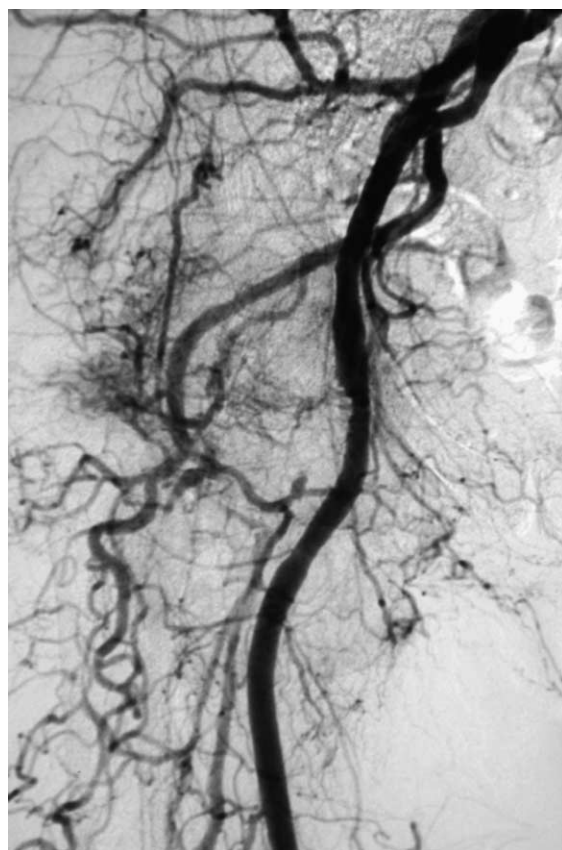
Vascular blush suggestive of a neoplastic process in a per femoral angiogram performed with digital subtraction after the CT shown in Fig. 2 (note: the profunda femoris artery was ligated at her initial operation).
